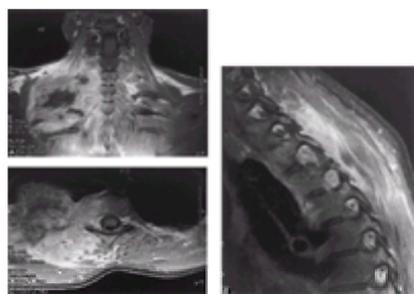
A: Coronal T1-weighted magnetic resonance imaging scan showing a right apical lung mass with invasion into the spinal canal. B: Sagittal T1-weighted magnetic resonance imaging scan (postgadolinium) showing tumor spread into right T-2 and T-3 vertebral foramina with mass infiltration of posterior spinal elements. C: Axial T1-weighted magnetic resonance imaging scan showing mass in apex of right lung and right paravertebral muscles extending into T-2 vertebral body and foramen.
